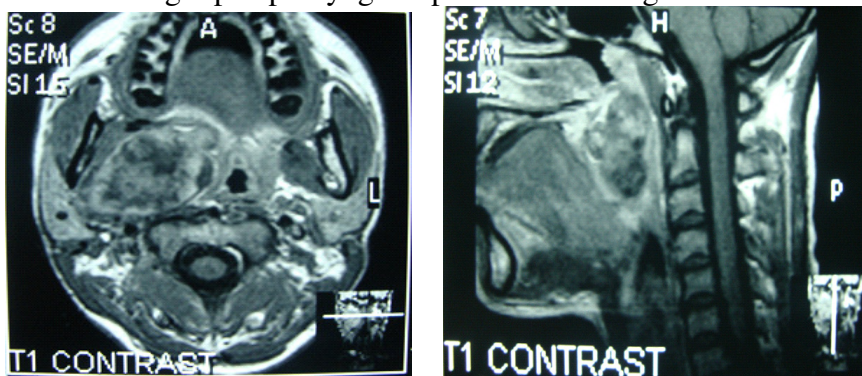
MRI shows a heterogeneous hyperintense signal mass in deep lobe of the right parotid gland.
